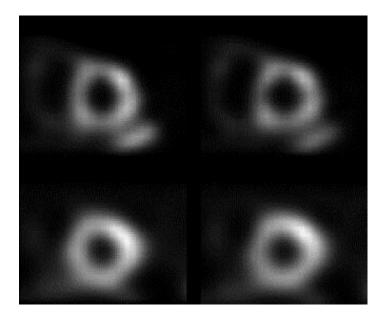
Flattening of the septum seen in short axis view with prominent right ventricle on the gated SPECT imaging in a patient with systolic pulmonary arterial pressure of 51 mmHg and history of COPD
